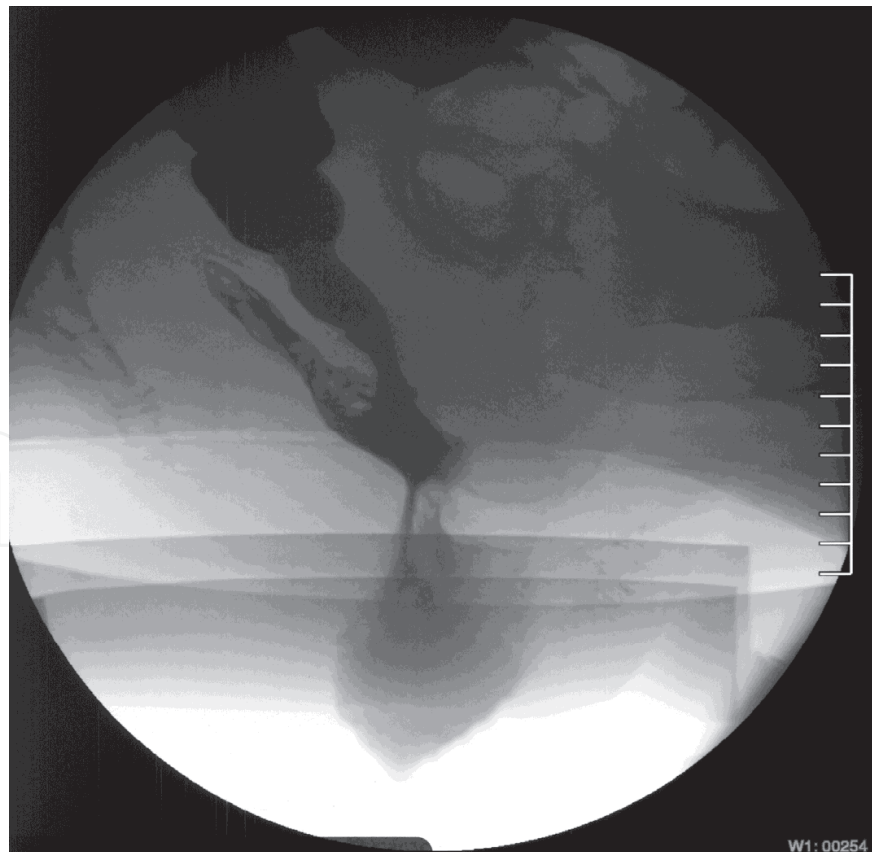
Radiographically proven old anastomotic leakage that presented years later with outlet obstruction.
